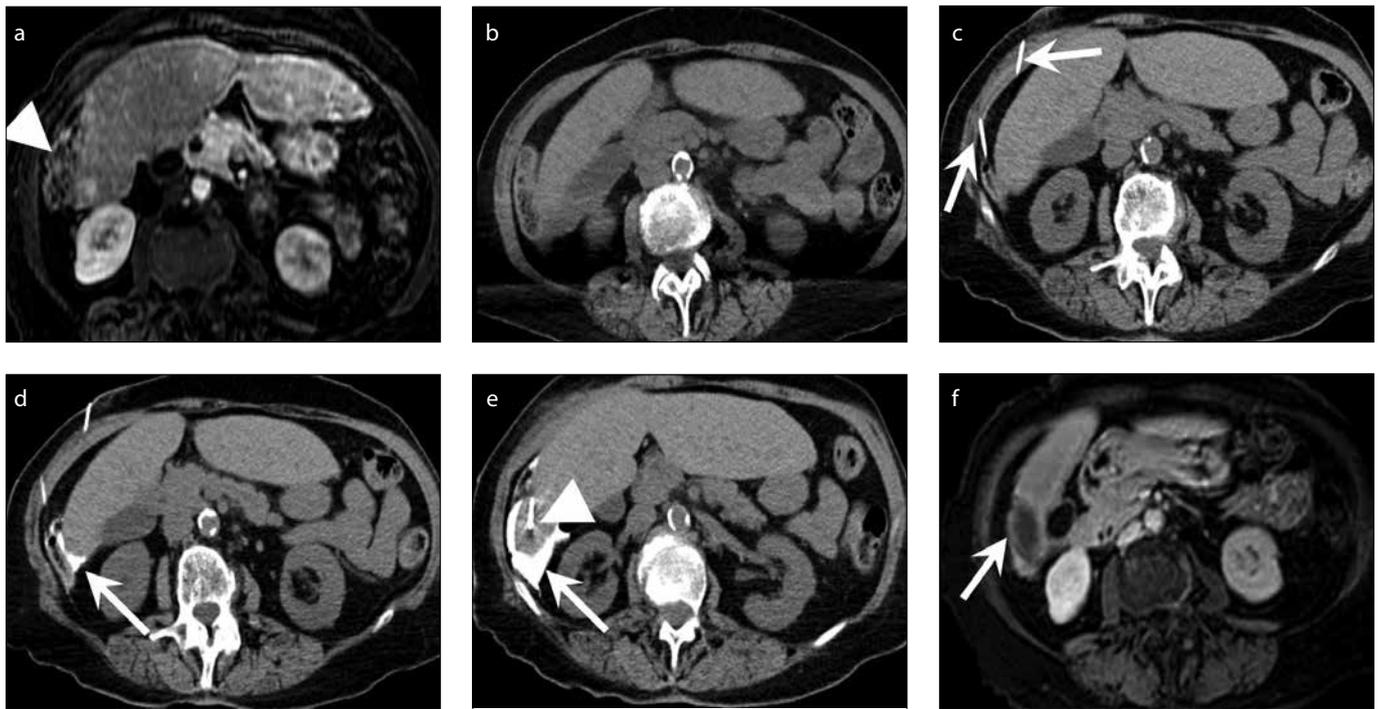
a–f. Contrast-enhanced MRI (a) shows a hypervascular mass within segment 6 of the liver. The colon (arrowhead) is noted to abut this area of the liver with no window for safe ablation. Unenhanced CT images prior to ablation (b, c) demonstrate the narrow window between the liver and colon. Two needles are positioned in the peri-hepatic space under CT-guidance (c, arrows). CT images (d, e) show injection of contrast-loaded fibrillar collagen in order to displace the colon. Early injection (d) demonstrates the needles to be in adequate position with fibrillar collagen filling the space between the colon and the liver (arrow). Continued injection of fibrillar collagen (e) adequately displaces the colon away from the mass and a microwave ablation probe is seen positioned into the segment 6 mass prior to ablation (arrowhead). Contrast-enhanced MRI post-ablation (f) demonstrates no residual enhancement of the mass (arrow) and no injury to adjacent structure.
